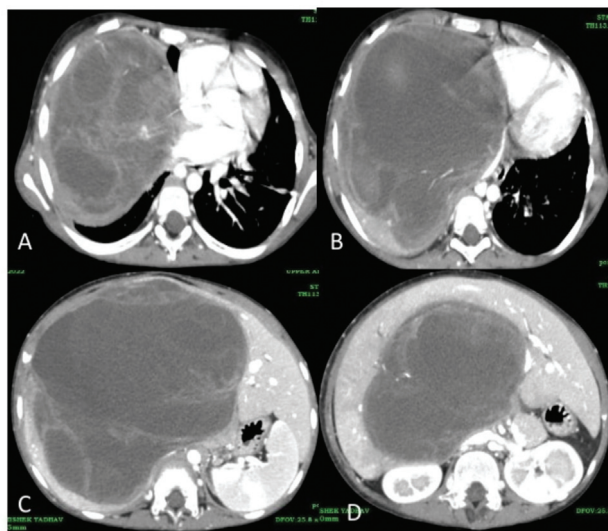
(A–D) Post-chemotherapy contrast-enhanced computed tomography (CECT) axial sections in venous phase shows marked reduction in septal enhancement and solid components.
